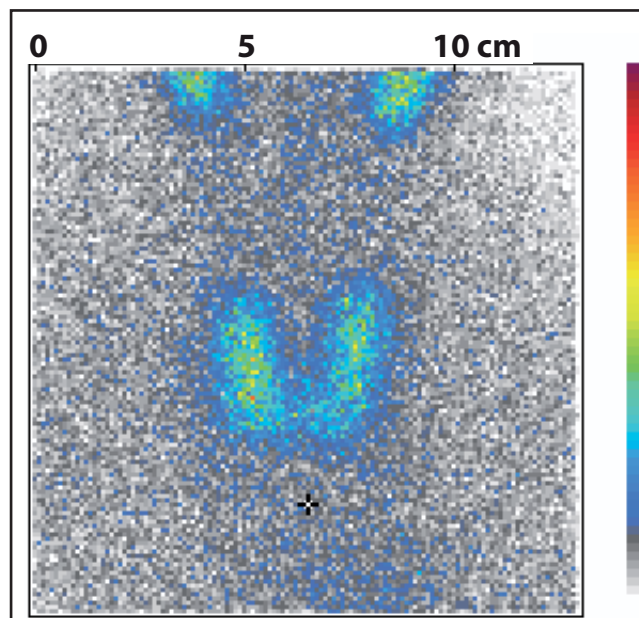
Thyroid ^{99m}Tc scintigraphy – regular accumulation of isotope in the thyroid gland.
